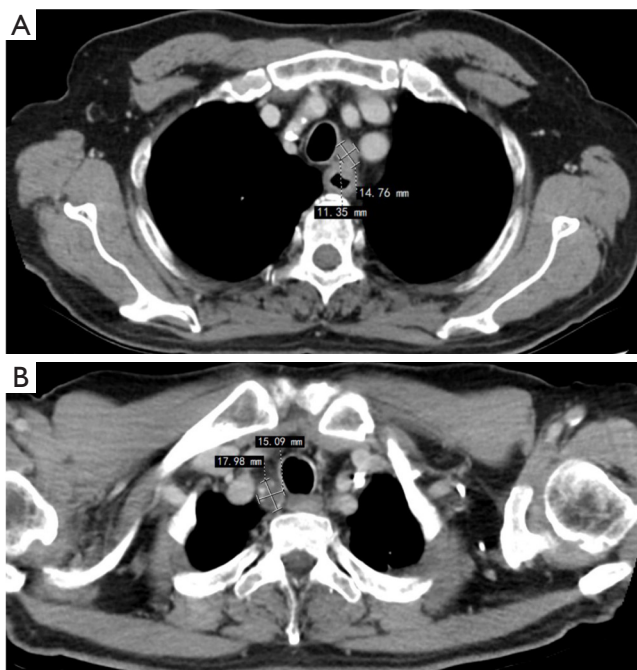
The long and short axes of the bilateral RLN LNs measured by a contrast-enhanced CT scan. (A) Left RLN LN; (B) right RLN LN. RLN, recurrent laryngeal nerve; LN, lymph node; CT, computed tomography.
